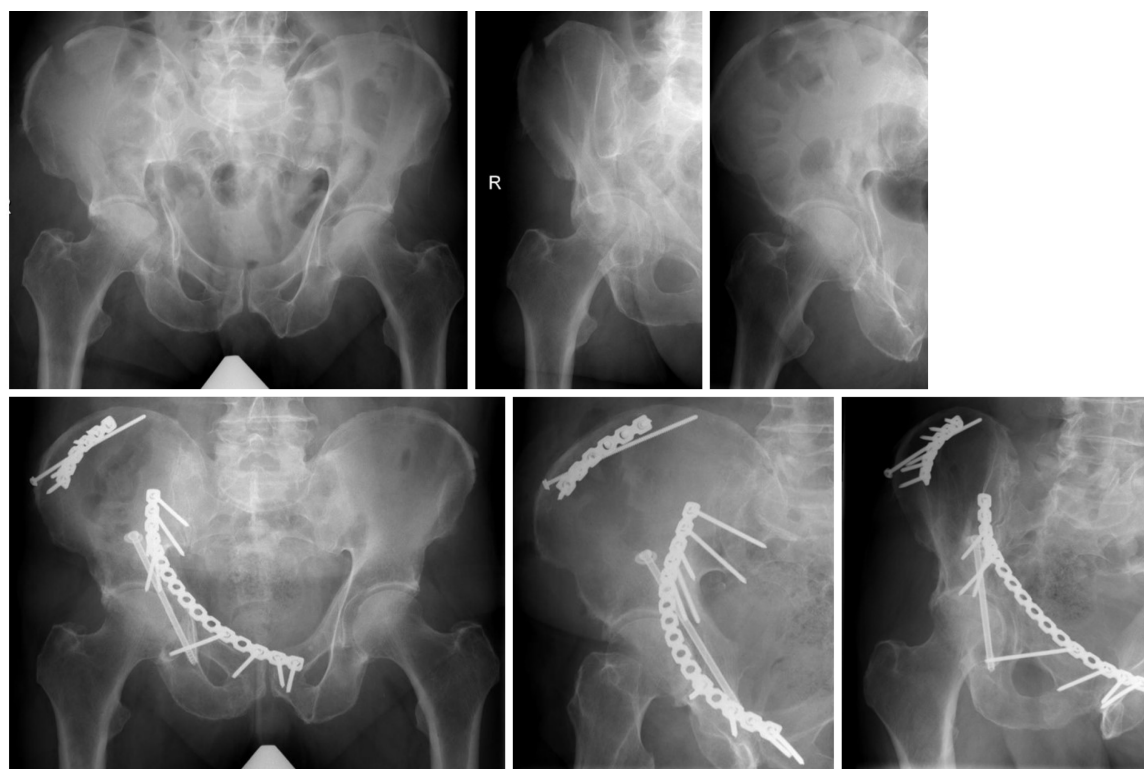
Initial X-rays of a patient with a both column fracture of the right acetabulum and follow-up X-rays 3.6 years after injury.
